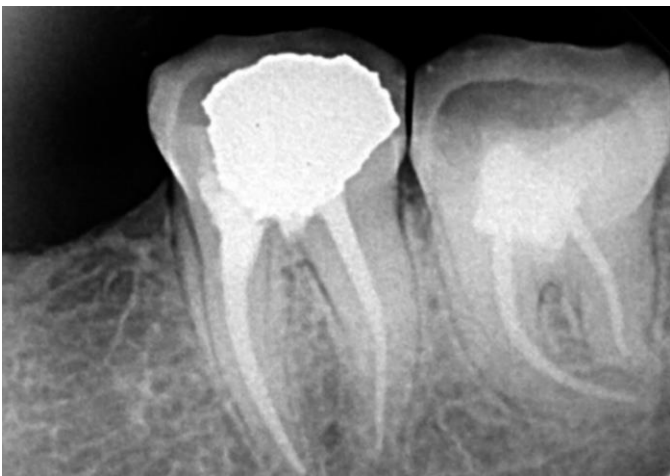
D: Post Obturation Radiograph
